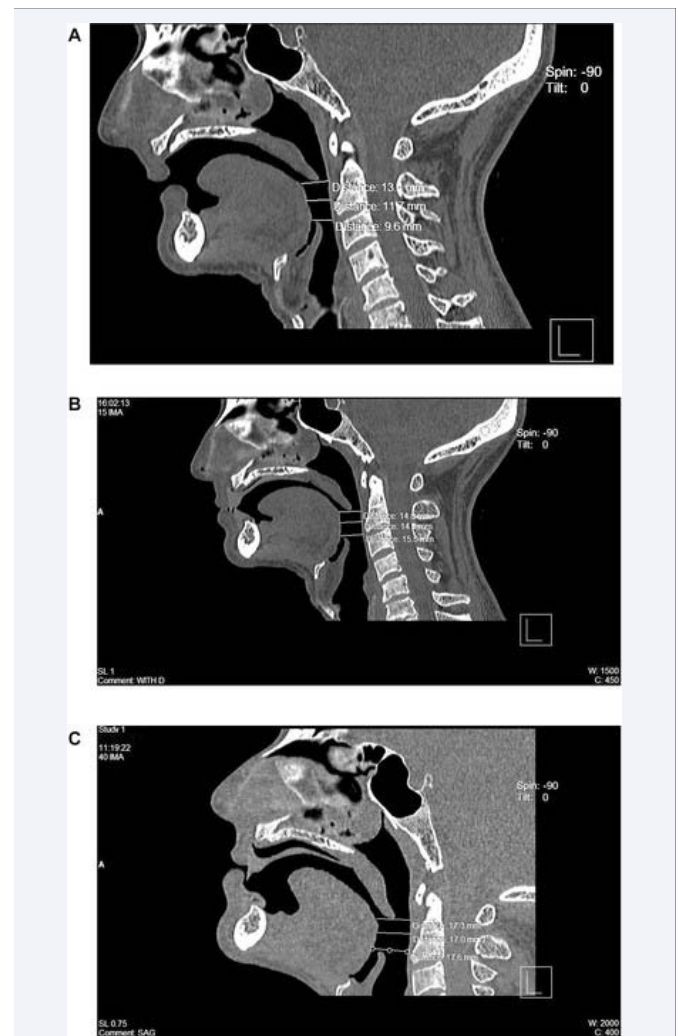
(A) CBCT image of the patient without denture
